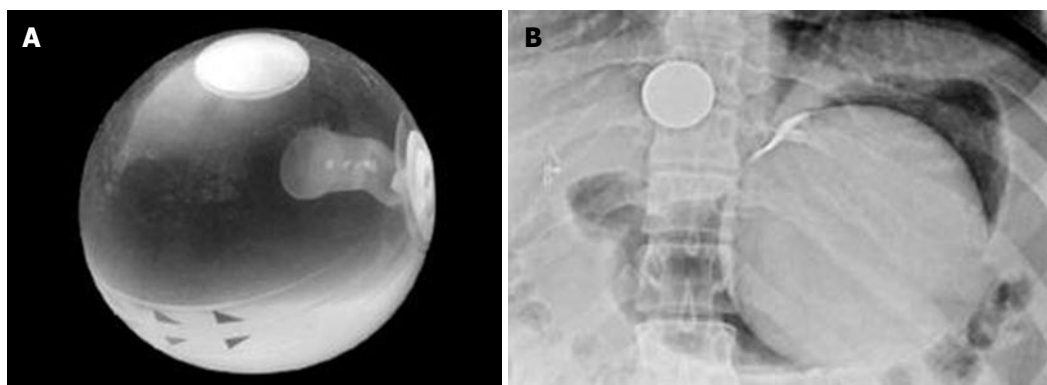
The BioEnterics Intra-gastric Balloon. A: The balloon is smooth and spherical. The arrows at the equator point toward the valve. The radiopaque self-sealing and re-penetrable valve with its Z-shape configuration (visible inside balloon) allows adjustment of the balloon volume from 400 to 800 mL; B: Plain abdominal radiograph showing balloon in body of stomach. A coin taped on the lower sternum permits follow-up comparisons of balloon size to detect premature deflation.
